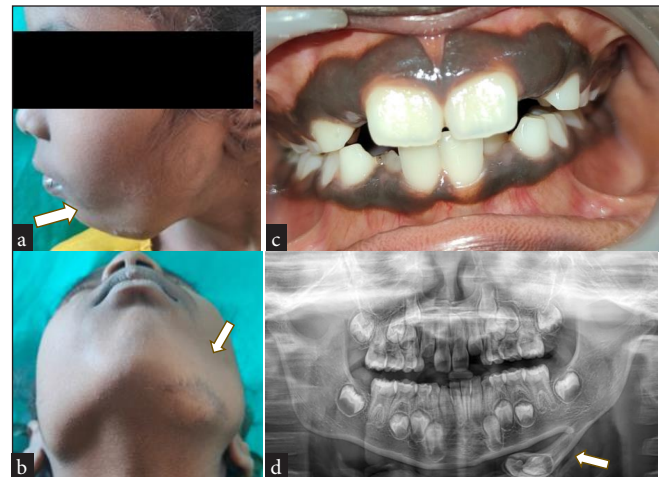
(a and b) White arrow showing Diffuse extraoral swelling in the left lower border of mandible with surgical scar, (c) Intraoral view showing no abnormalities, and (d) White arrow in orthopantomogram showing extraosseous bony growth with enclosed tooth buds.
